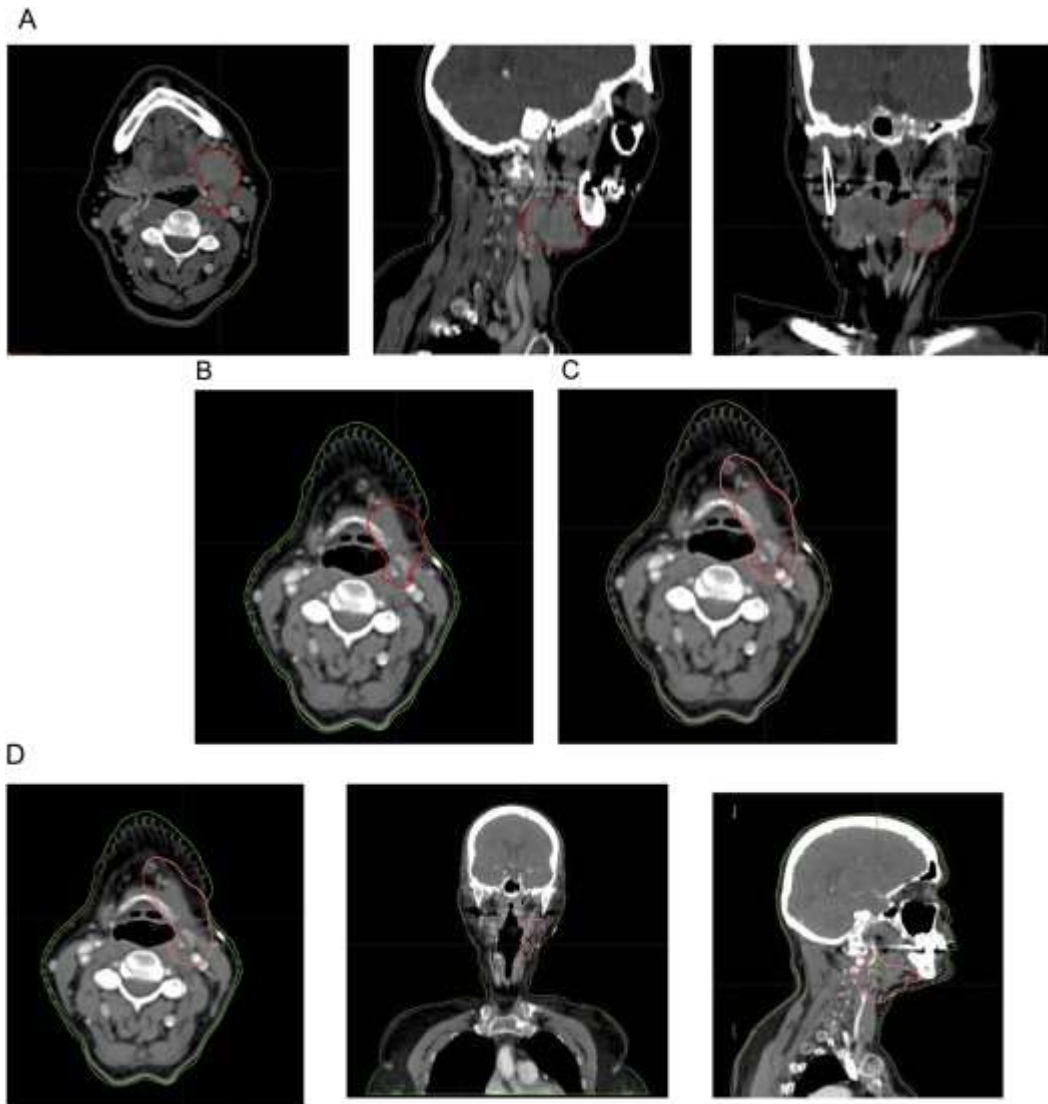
(A-D) Patient with diffuse large B-cell lymphoma Clinical Stage (CS) 1A in the left neck. (A) Prechemotherapy CT scan with the contoured initially involved lymphoma volume (GTVCT) in red. (B) Postchemotherapy planning CT scan with the prechemotherapy GTVCT transferred by image fusion. (C) Postchemotherapy planning CT scan. The clinical target volume in pink is the tissue volume that contained lymphoma initially. It is created by modifying the GTVCT to take into account tumor shrinkage and other anatomic changes, allowing for uncertainties in contouring and differences in position. (D) The postchemotherapy planning CT scan with the final clinical target volume, which encompasses all of the initial lymphoma volume while still respecting normal structures that were never involved by lymphoma.
